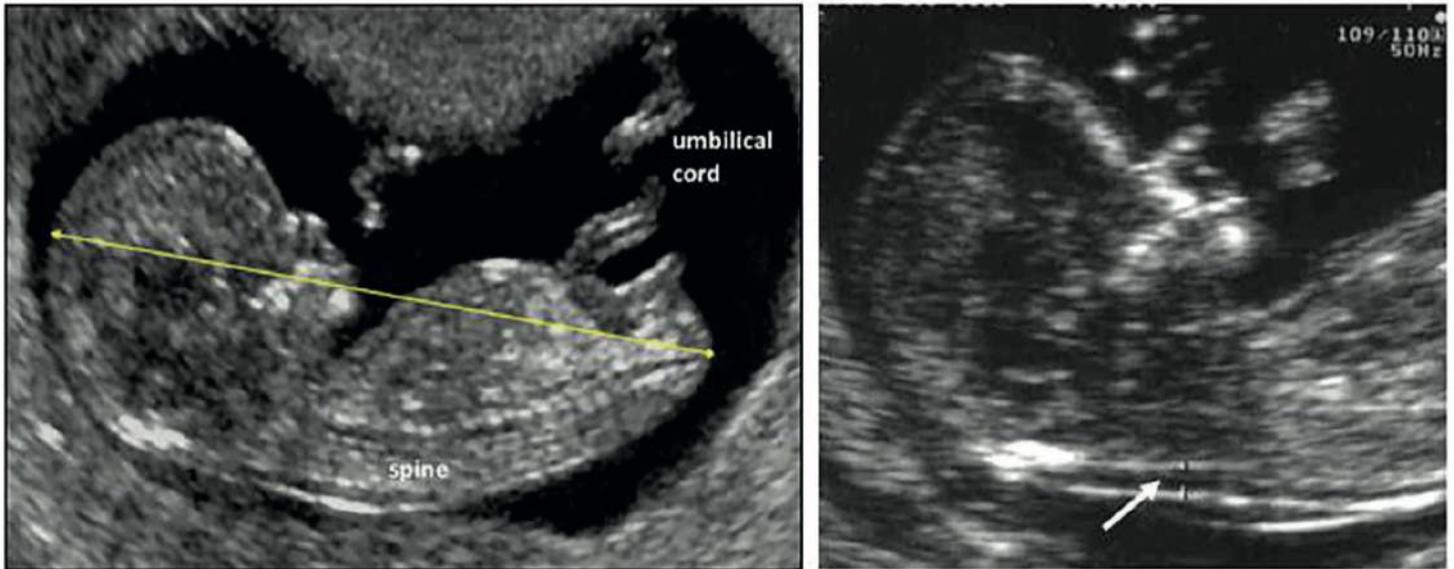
Ultrasound images demonstrating the measurement of crown–rump length (left-hand image) and nuchal translucency (arrow, right-hand image).
